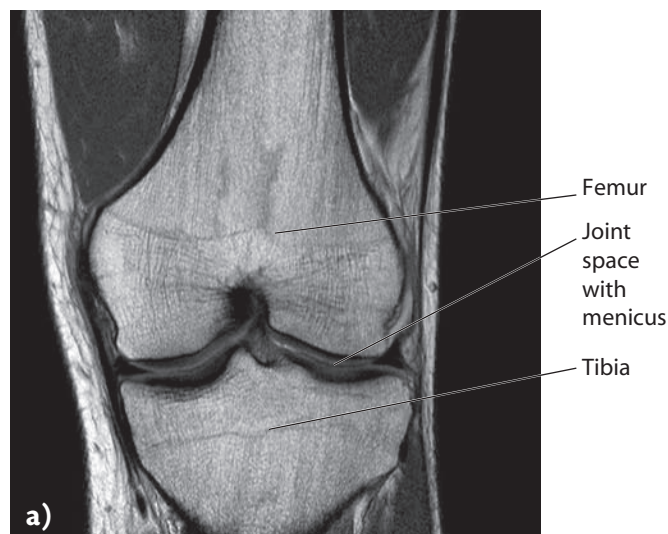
Magnetic resonance imaging (MRI) of the knee.
